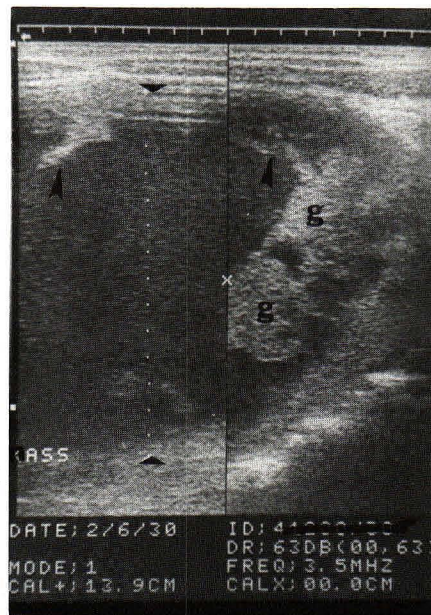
A longitudinal sonogram shows a thick-walled cystic mass (><) with septation (arrow heads) and nodular growths (g).
